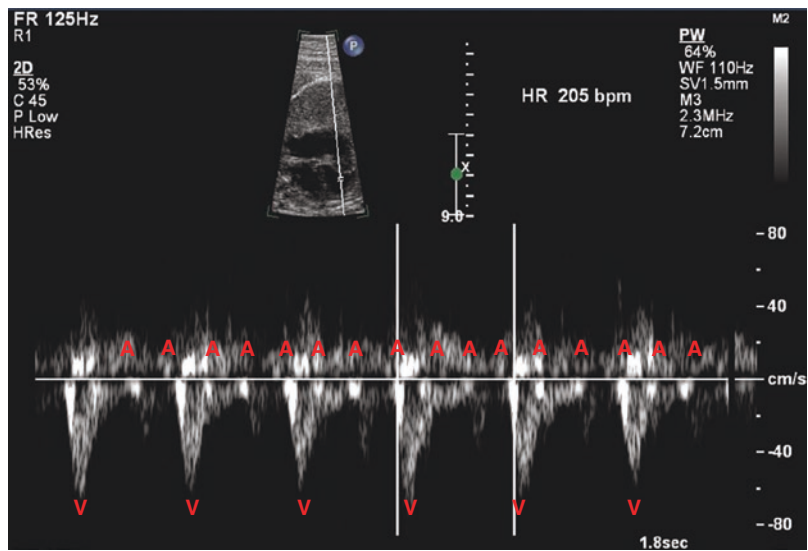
SVC–Ao Doppler showing AF. The ventricular rate is 205 bpm
